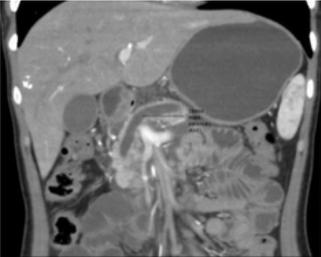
CT scan showing hypodense mass involving the uncinate process of pancreas and dilated common bile duct and pancreatic duct.
